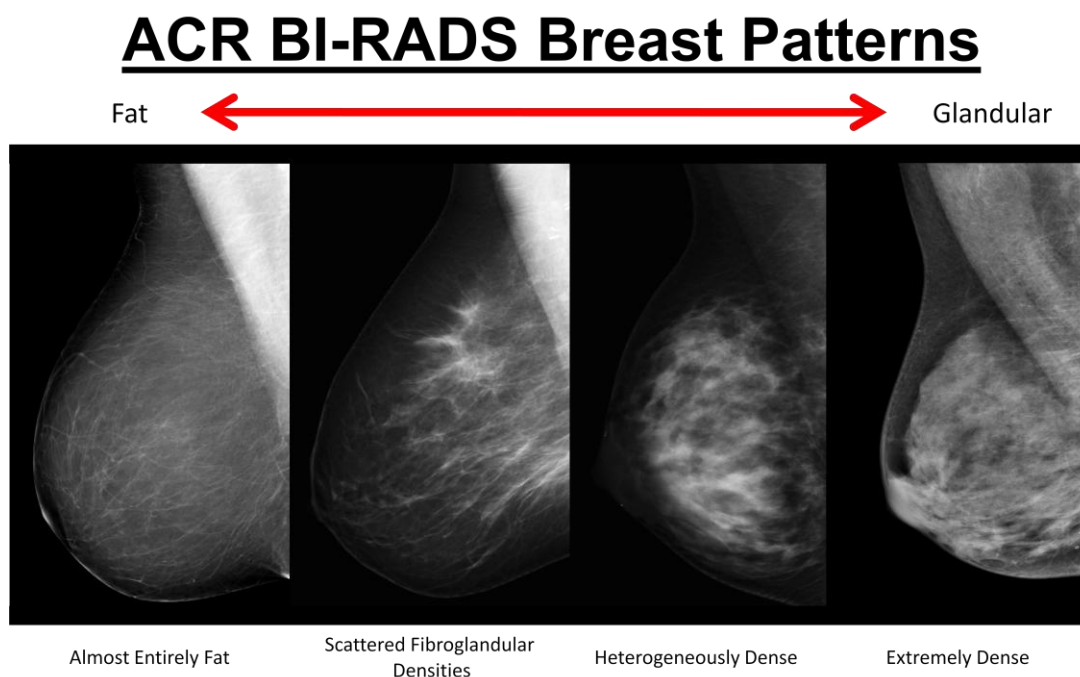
Example 2D projection radiographs of breasts with each BI-RADS density classification. Moving from left to right the densities become more dense. This image is reprinted with permission from Dr. Cherie Kuzmiak from UNC Hospitals.
